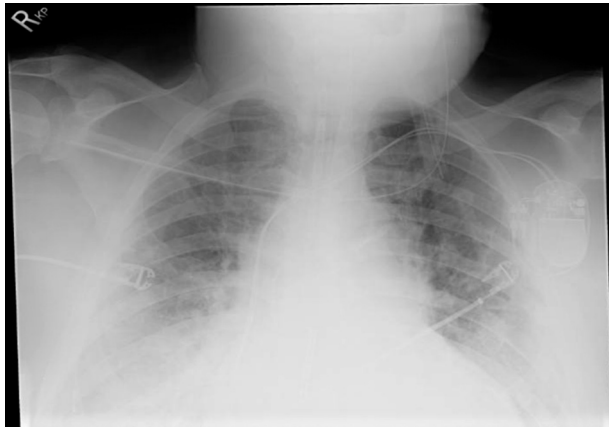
Presenting chest radiograph showing pulmonary edema and congestion.
